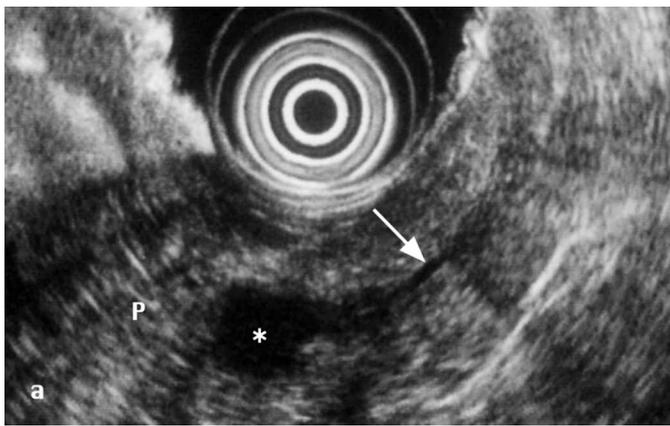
Insulinoma (*) located in the body of the pancreas imaged by EUS (a) and MRI (b). P = Pancreas, L = liver, N = left kidney.
